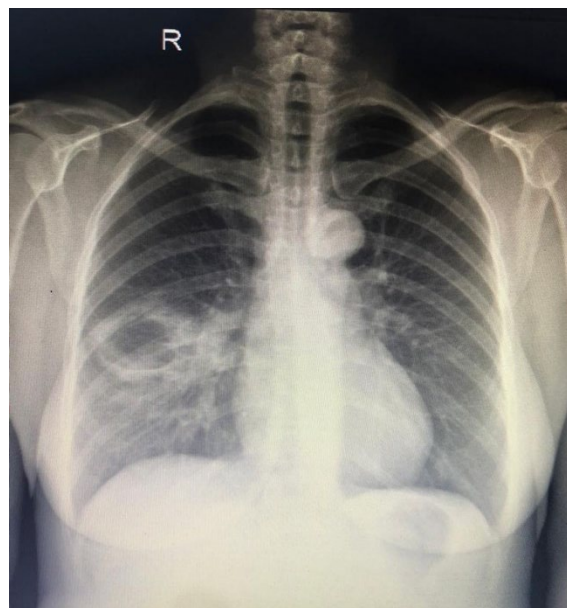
Chest X-ray on admission showed a hyper-transparent circumscribed lesion with a thick, anfractuous contour adjacent to the right pulmonary hilum.
